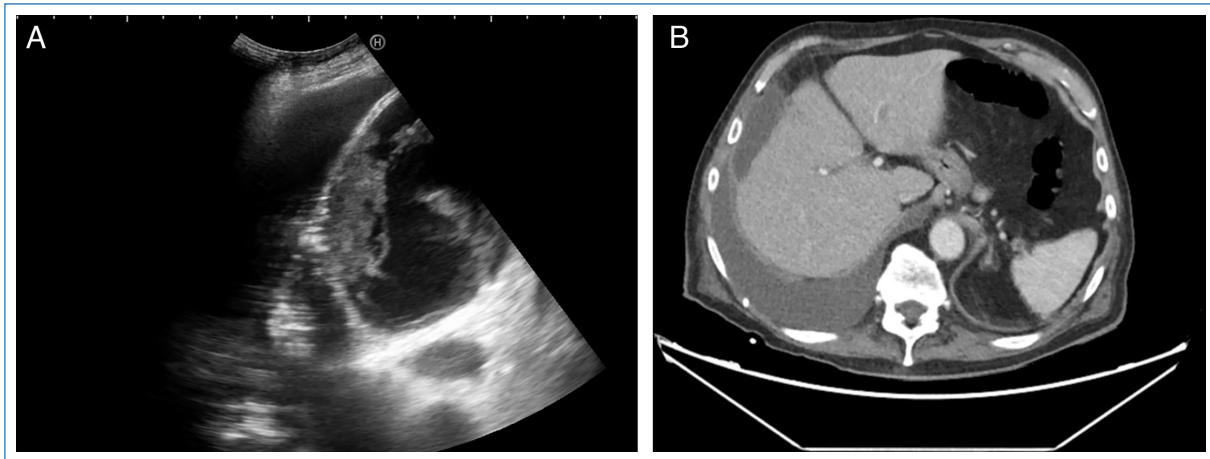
A: thoracic ultrasound showing anechoic pleural effusion and a subphrenic collection with debris inside. B: axial cut of the thoraco-abdominal CT scan showing right pleural effusion with a collection in the recess and a defect in the diaphragmatic dome.
